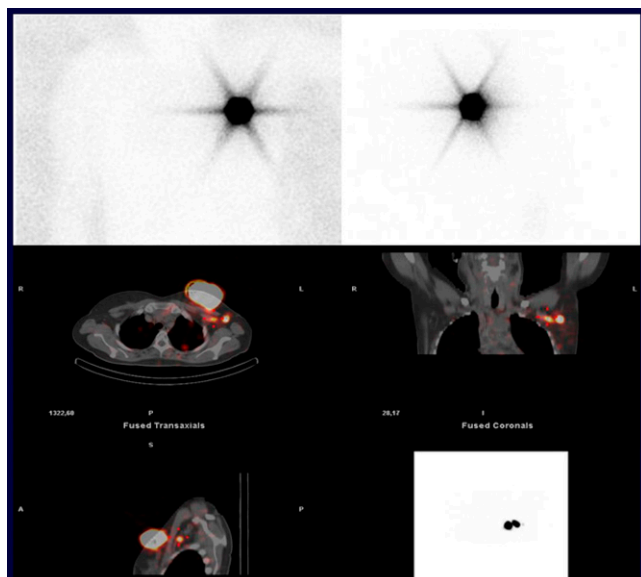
Planar imaging versus SPECT/CT sentinel lymph node imaging in a 49-year-old woman with a tumor (T2N0M0) in the upper inner quadrant of the left breast. Top: no sentinel lymph node (SLN) is visible on planar anterior and left lateral images. Bottom: Two axillary SLNs are visible on SPECT/CT directly behind the tumor, demonstrating the utility of SPECT/CT over planar imaging for this assessment.
